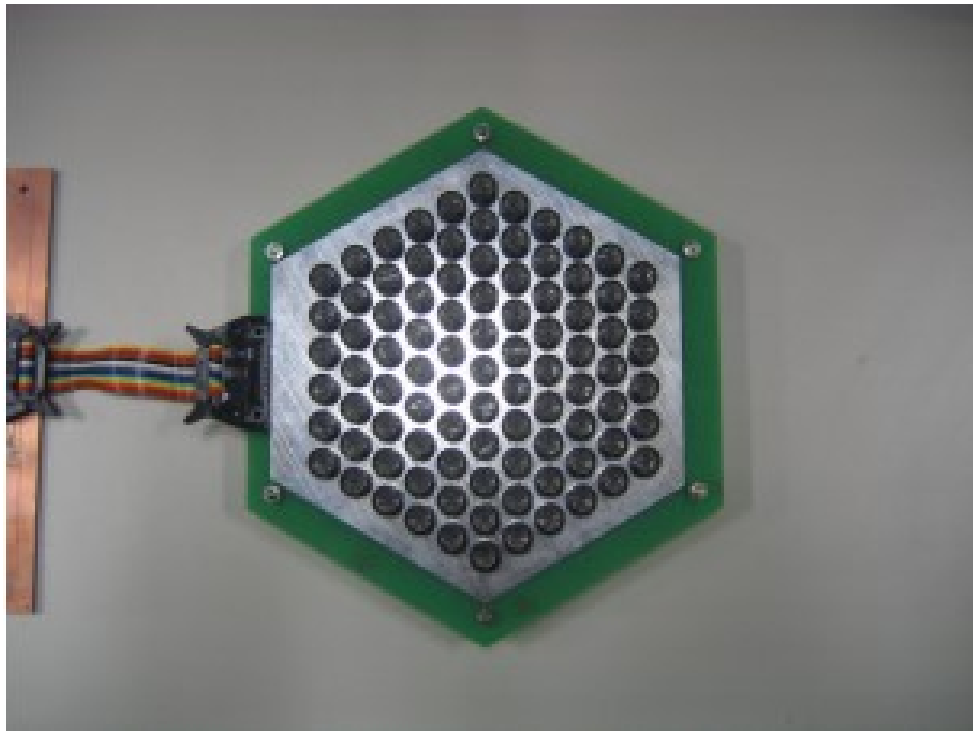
The front side of an annular array of airborne ultrasound transducers. [2]. Reproduced with permission from Springer Nature
